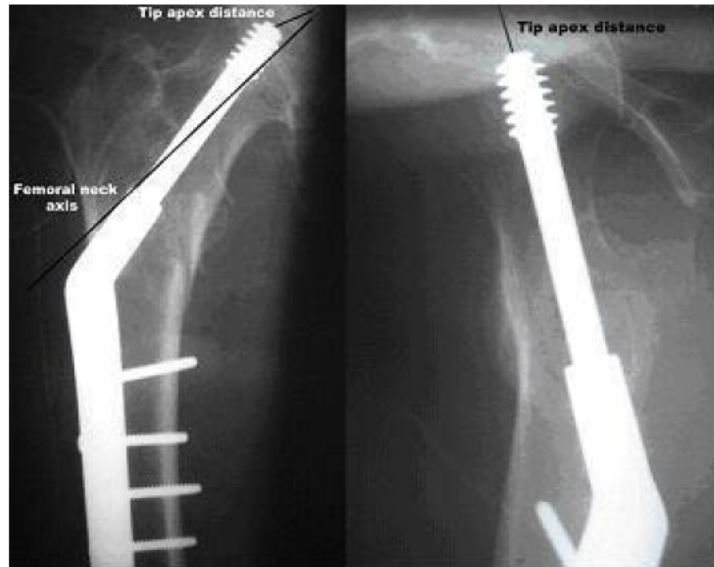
Postoperative AP (left) and lateral (right) radiographs of 135° sliding hip screw fixation of the same fracture. The long black line represents the femoral neck axis and terminates on the margin of the femoral head. The short black lines in both films represents the tip-apex distance (tip of lag screw to apex of femoral head; TAD). In the AP film it measured 1.25cm and 2.7cm in the lateral. The combined TAD was 3.95 cm
